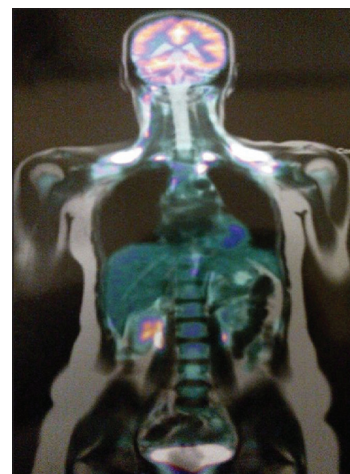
Whole body 18-FDG PET-MRI
